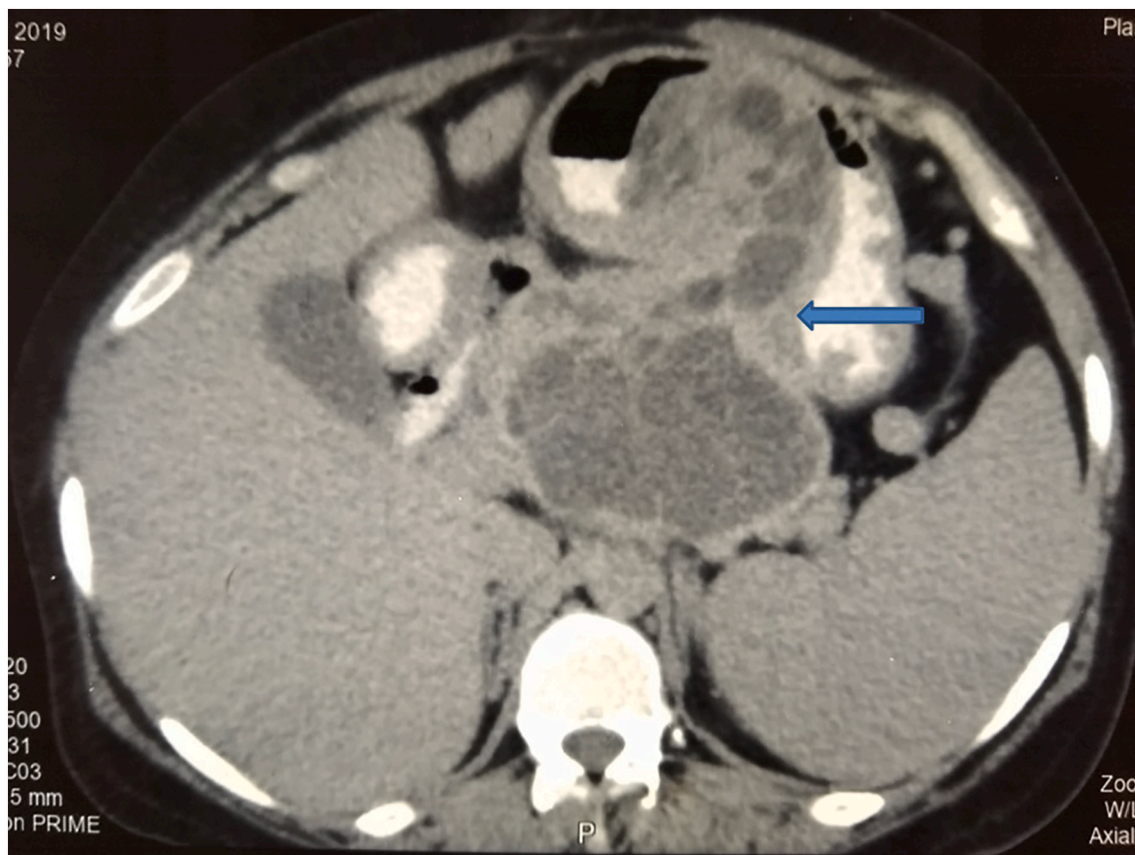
Computed tomography scan of the abdomen showing a well defined multiloculated cystic lesion (11.8x 11.1x6.4 cm) in the body and tail of the pancreas with involvement of the stomach.
